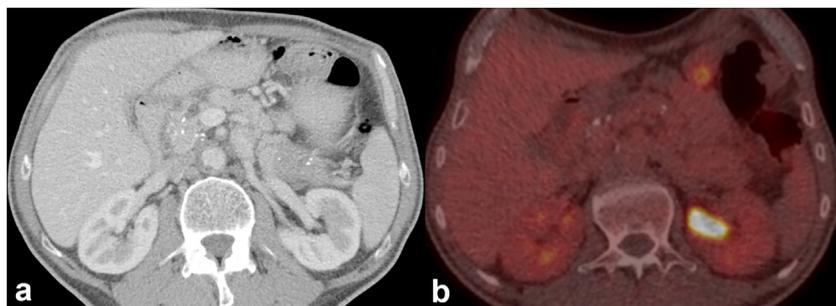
A 56-year-old male with T2N1 PDAC of the pancreatic tail who underwent distal pancreatectomy with an overall survival of 6 months. The tumor (25 mm) was hypoattenuating on CECT (a) and showed low [^{18}F]FDG-uptake on PETCT (b)
